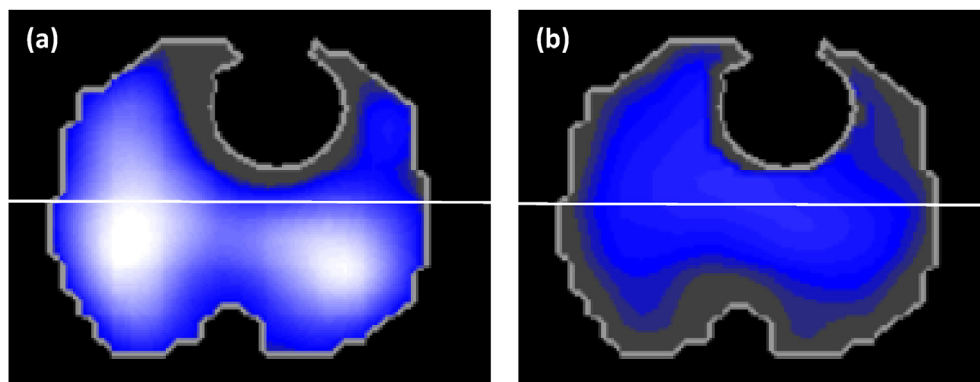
EIT ventilation distribution map before and after administration of rocuronium. The image represent a transverse plane at the level of the 5th intercostal space. Anatomical positioning is equal to CT imaging. Dark grey areas indicate no ventilation. White areas indicate high TIV, with decreasing TIV towards darker colors. (a) The fraction of regional TIV before administration of rocuronium was 25% and 75% in the non-dependent and the dependent regions, respectively. (b) After administration of rocuronium, global TIV decreased to 35% of that of before administration. The fraction of distribution of global TIV after rocuronium administration was 43% and 57% in the non-dependent and the dependent regions, respectively. (For interpretation of the references to colour in this figure legend, the reader is referred to the web version of this article.)
